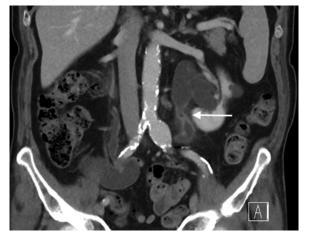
Portovenous phase CT imaging shows extensive mural enhancement of the ureters bilaterally (left worse than right) with subsequent stricturing and upstream hydronephrosis consistent with upper tract recurrence (arrow).
